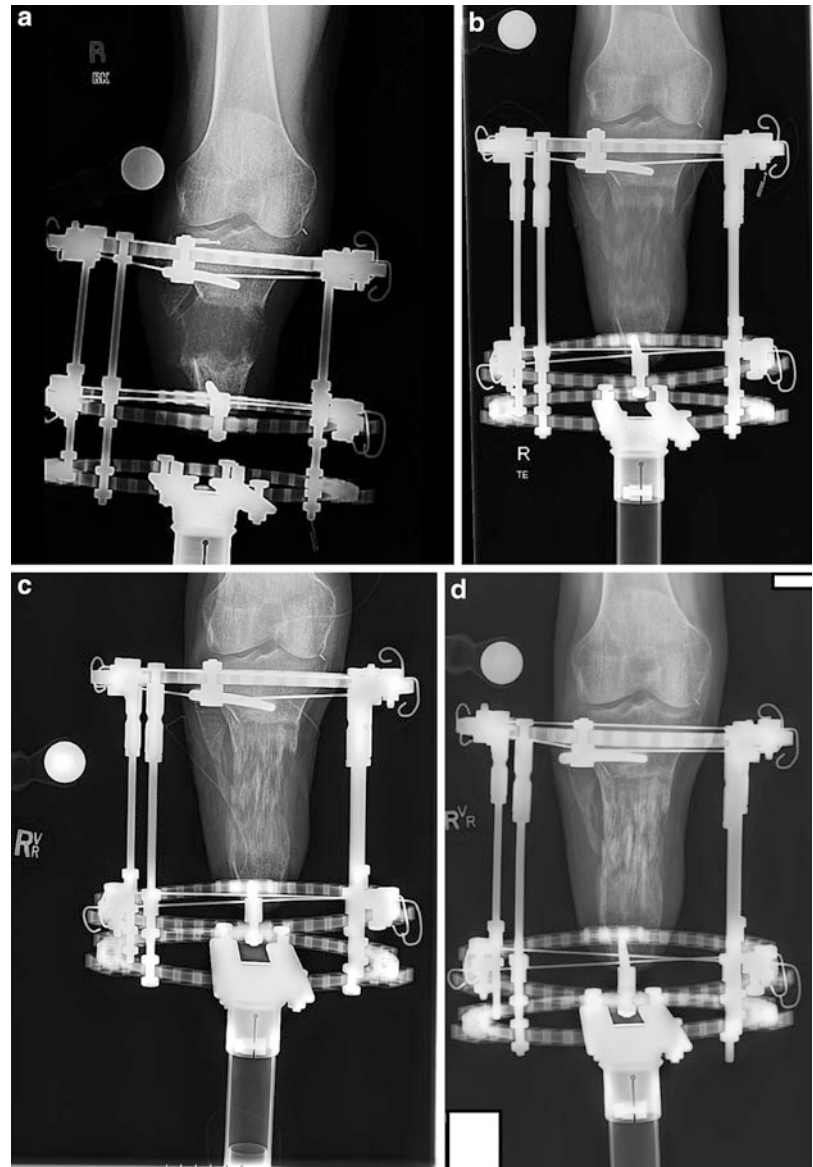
(a–d) (a) AP X-ray at 2 months after surgery showing distraction gap. (b) AP X-ray at 6 months after surgery. (c) AP X-ray 8 months after surgery showing progression of union. (d) AP X-ray 11 months after surgery
